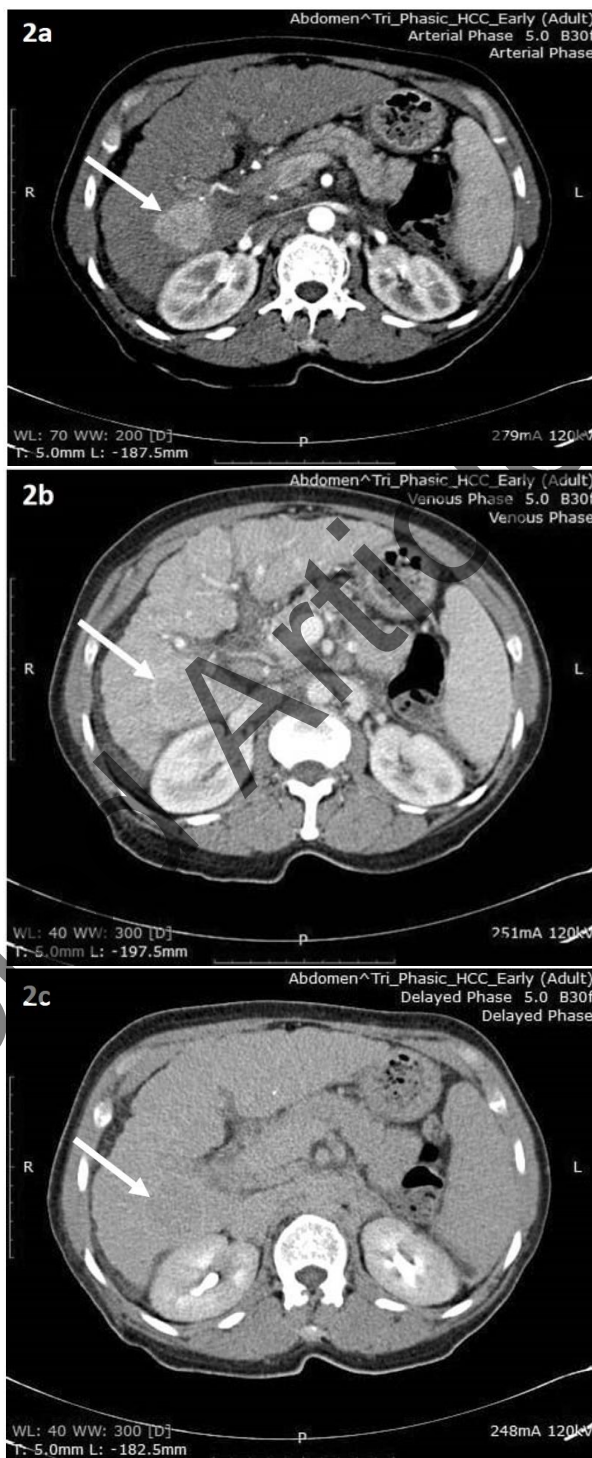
2a, 2b and 2c show arterial, venous and delayed phases of triphasic CT scan respectively in a 52 year old, HCV positive woman with evidence of chronic liver disease. HCC is seen at segment VI/VII of the cirrhotic liver. Ascites can also be noted.
